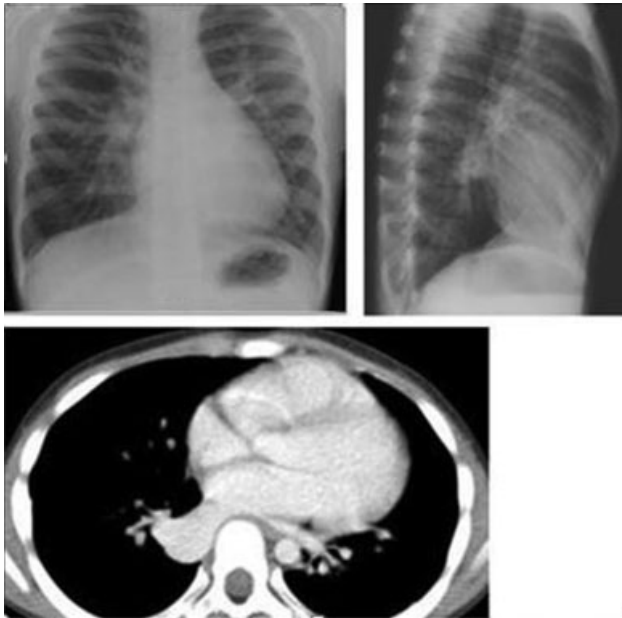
PA view of CXR shows bilateral anomalous curvilinear vessels in the lower pulmonary regions. MDCT with axial and coronal MIPs demonstrates bilateral pulmonary veins with anomalous routes in the lower pulmonary regions but draining normally into the left atrium. Coronal volume-rendering 3D reconstruction shows the anomalous veins and normal pulmonary arteries. PA, posteroanterior; 3D, three dimensional; MDCT, multidetector computed tomography.
